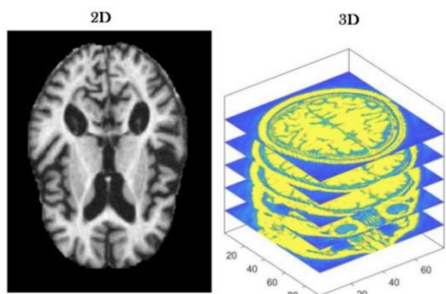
2D vs. 3D Brain MRI Images - The 3D image images allow for more layers to provide high-quality representations of the database. Modified from S. Dubey et al. (2020) and M. Liu et al. (2018)^{8,9}.
